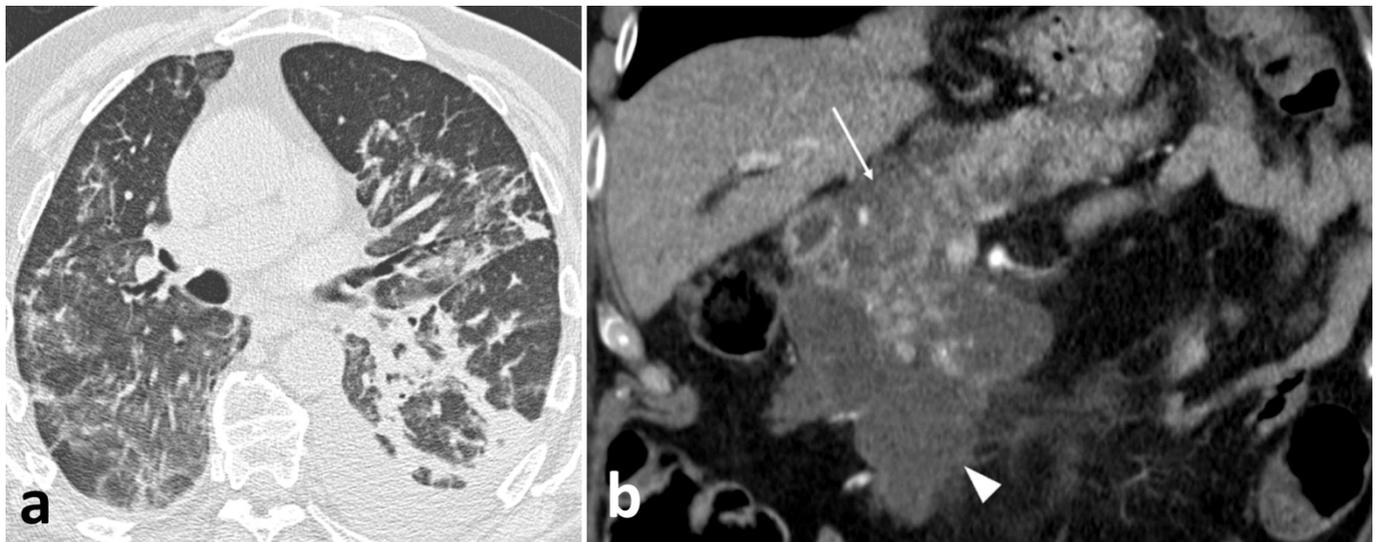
CT imaging. a) High resolution CT scan of the chest, showing extensive areas of ground-glass opacity, with strands of consolidation and left pleural effusion. b) Coronal arterial phase CT image shows areas of reduced parenchymal perfusion (arrow) and large peripancreatic collections (arrowhead).
